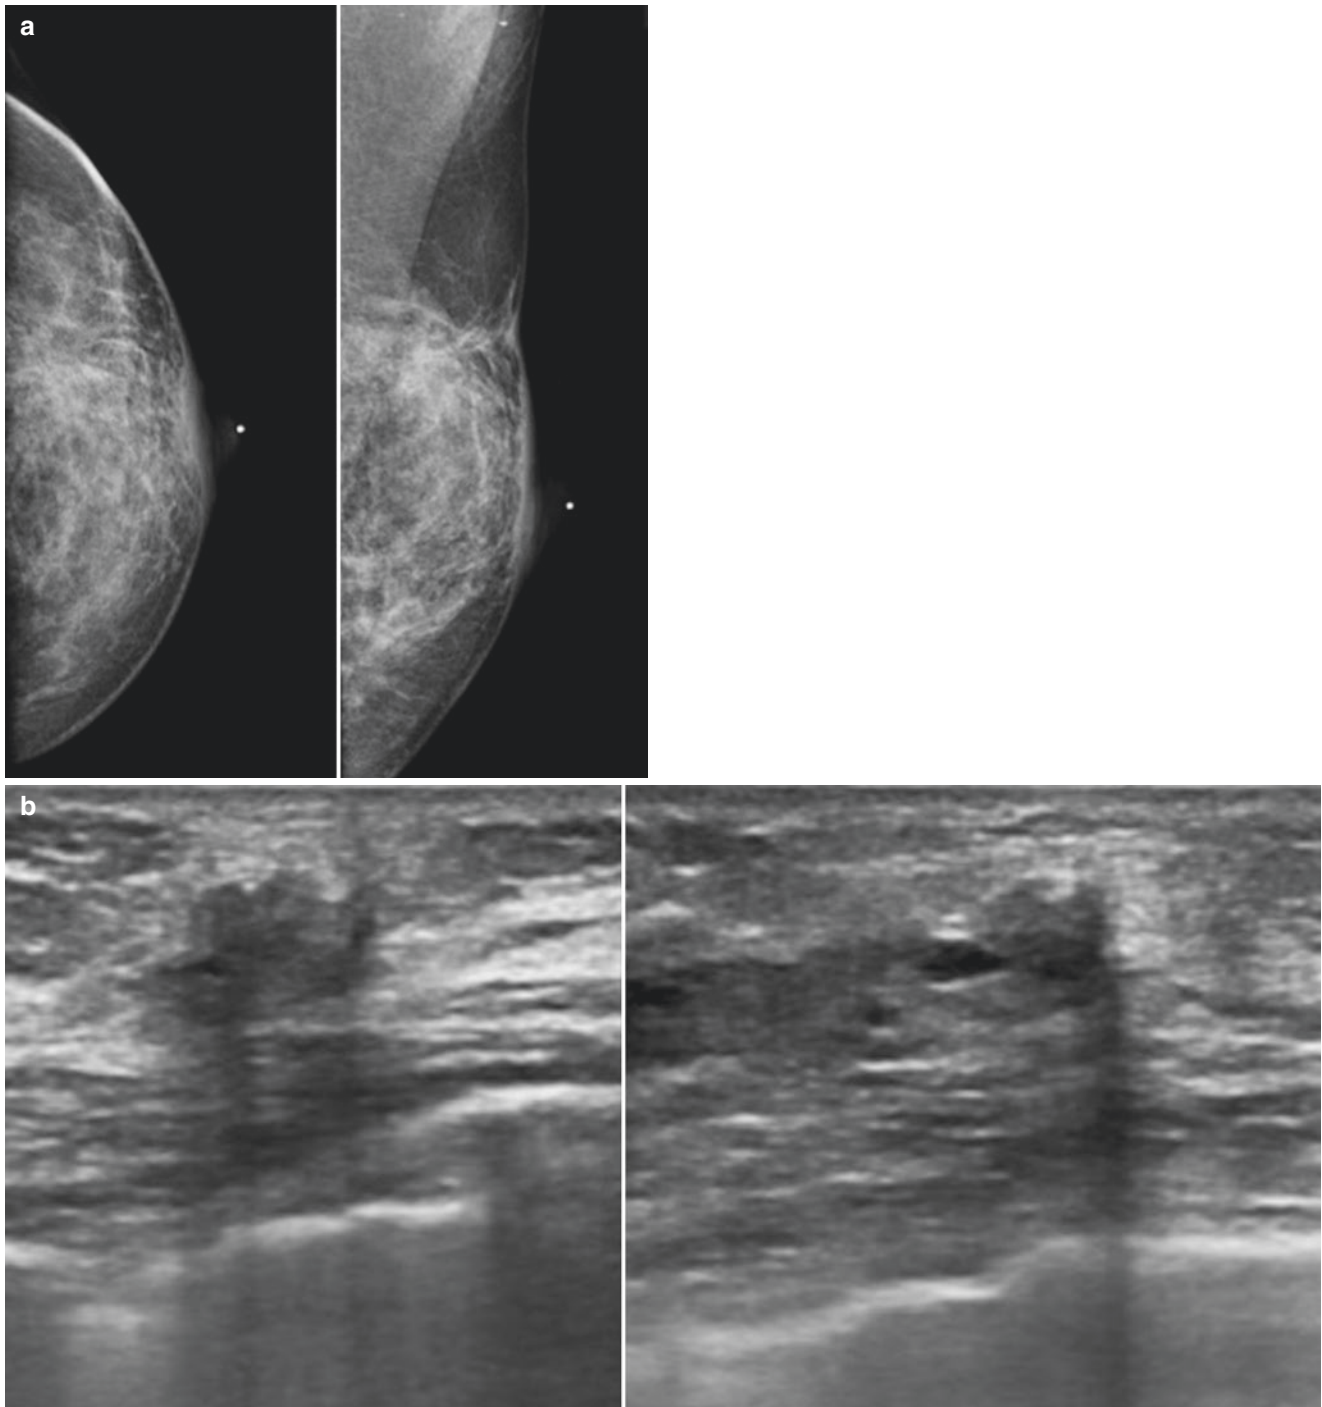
Patient with a personal history of breast-conserving surgery in OUQ left breast. (a) Mammography shows architectural distortion in the area of the scar. (b) Ultrasound shows a nodular lesion
